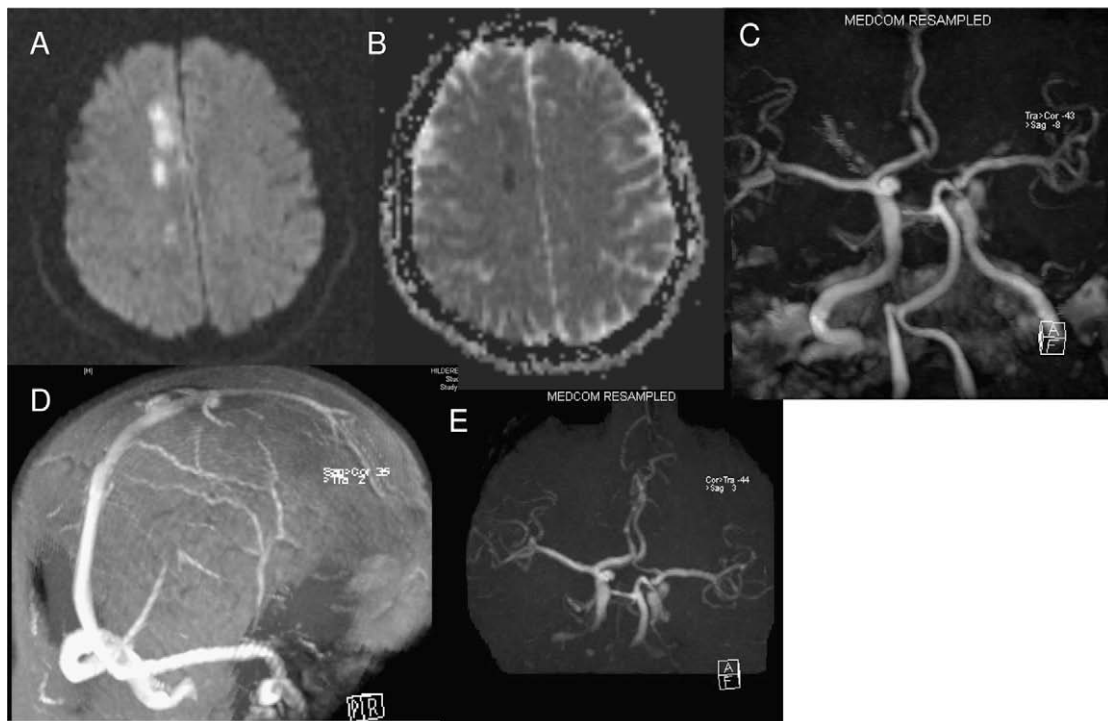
(A) An axial MRI diffusion-weighted image. (B) An apparent diffusion coefficient MRI. (C) A magnetic resonance (MR) angiogram of the brain. (D) An MR venogram. (E) A follow-up MR angiogram.
